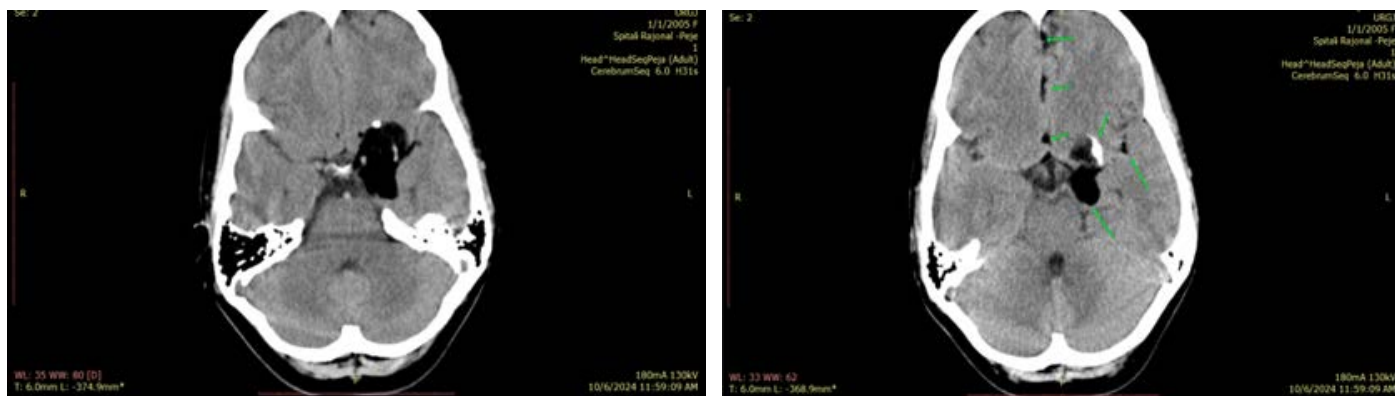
A 19-year old female with epidermoid cyst. FINDINGS: Axial contrast enhanced CT of the brain in the arterial phase demonstrates a hypodense lesion, measuring 15 Hounsfield unit (HU), with rim calcification. TECHNIQUE: Axial CT, 180mA, 130kV, 6 mm slice thickness, 90 ml of Iopromide.
